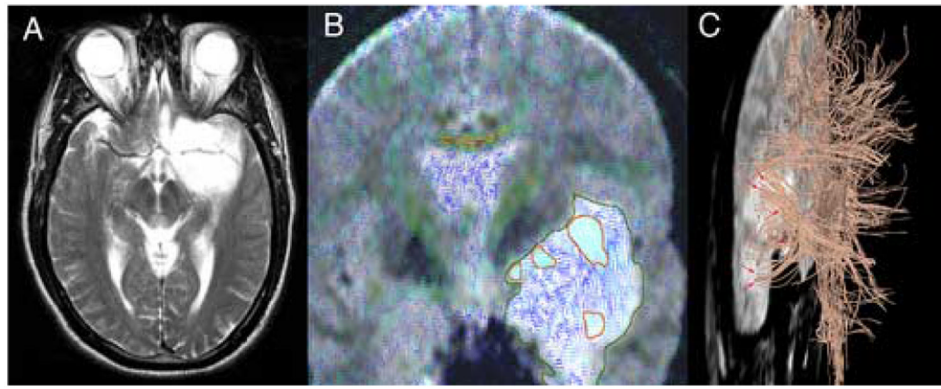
Left fronto-temporal Oligodendroglioma WHO II. A: axial T2-FSE; B: color-coded 2D-DT-MRI visualization overlaid on the corresponding T2-weighted slice; the tumor is outlined in dark green; areas of high fractional anisotropy (light-blue lines) within the tumor confines, corresponding to infiltrated white matter fibers, are outlined in red; C: 3D-tractography overlaid on the baseline T2-weighted acquisition (left lateral view); note the uncinus fasciculus (arrows) running through the T2-hyperintense tumor mass.
